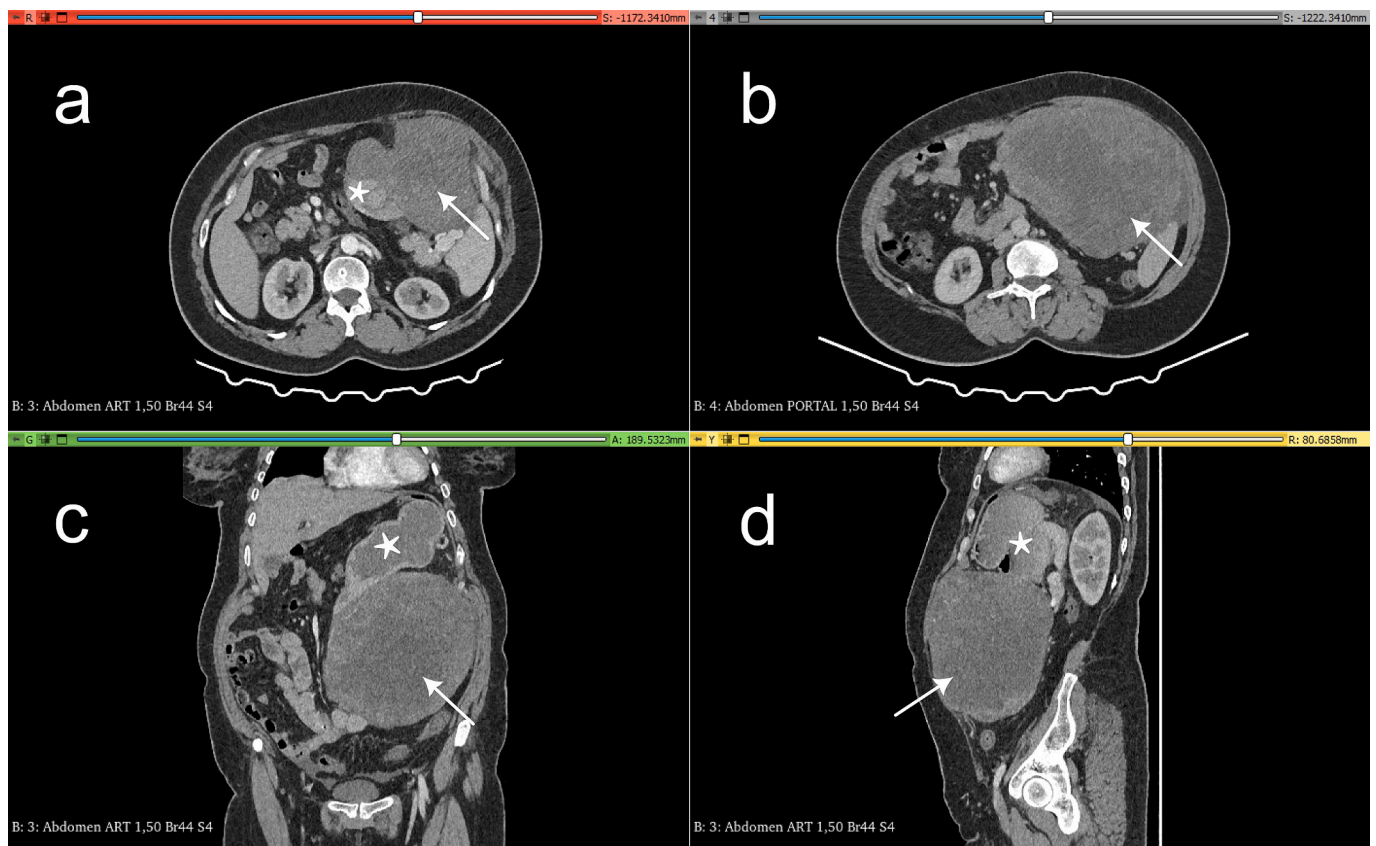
Preoperative CT scan. (a) Axial view arterial phase, (b) axial view portal phase, (c) coronal view arterial phase, and (d) sagittal view arterial phase showing a sizable tumor (White arrows) attached to the stomach (White stars), with heterogeneous density. No active bleeding was detected on this CT.
